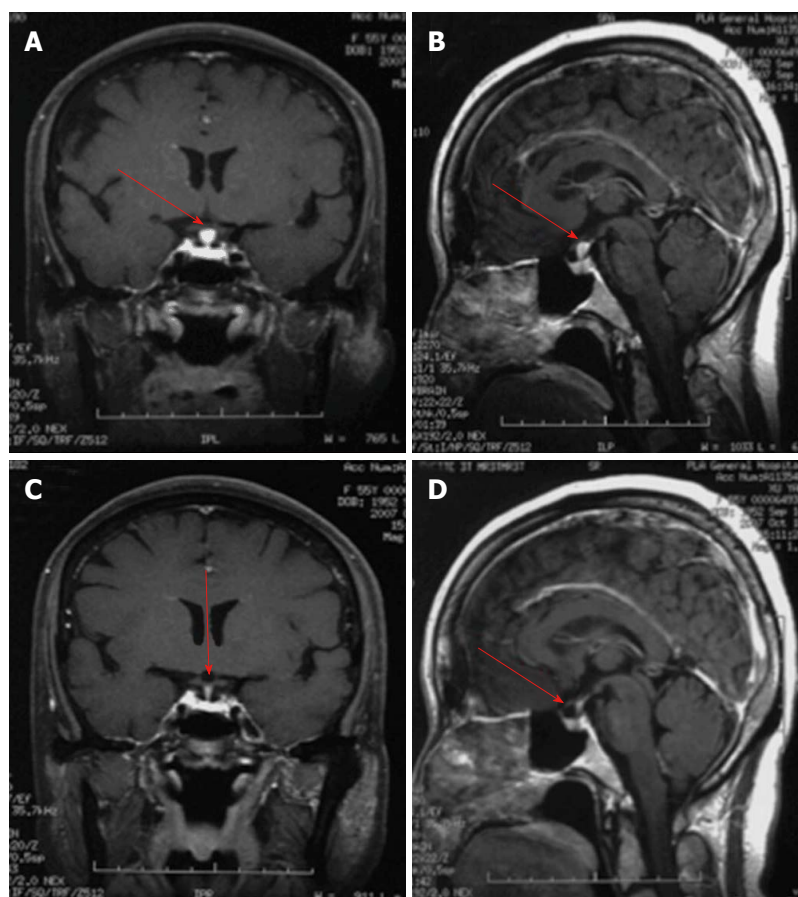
Involvement of the pituitary gland. Magnetic resonance imaging showed the change of pituitary stalk nodular thickening. A: Coronal view clearly showed pituitary stalk nodular thickening (arrow); B: Sagittal view clearly showed pituitary stalk nodular thickening (arrow); C: Coronal view showing a significantly reduced pituitary stalk (arrow); D: Sagittal view showed a significantly reduced pituitary stalk (arrow).
